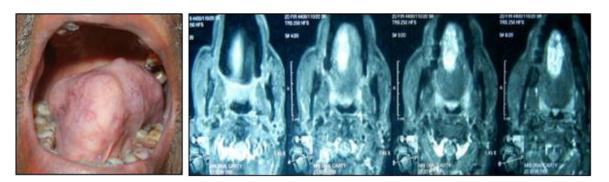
Preoperative clinical presentation and MRI (axial view) of tongue.
